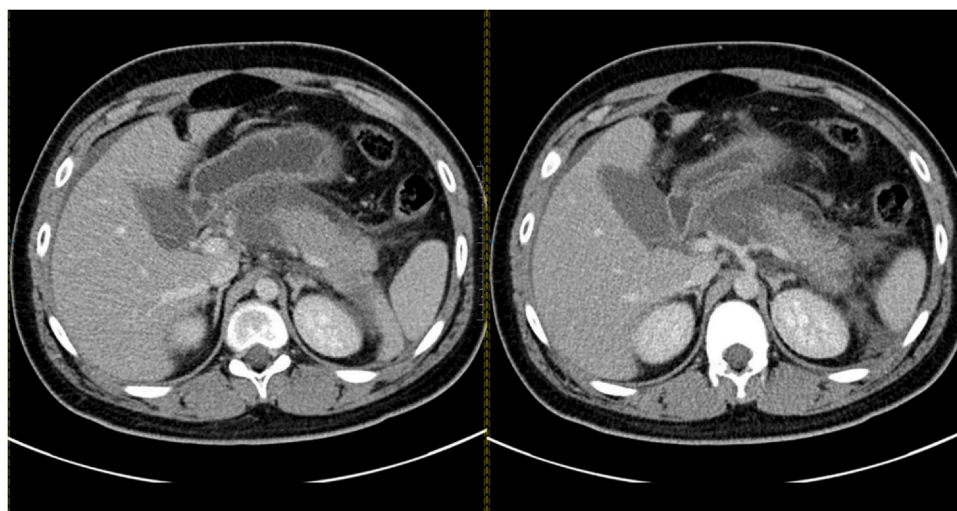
Contrast-enhanced abdominal computed tomography (CT) showing non-enhancing low attenuation areas at the neck and body of the pancreas constituting 20–30% of pancreatic tissue, in keeping with acute necrotizing pancreatitis.
